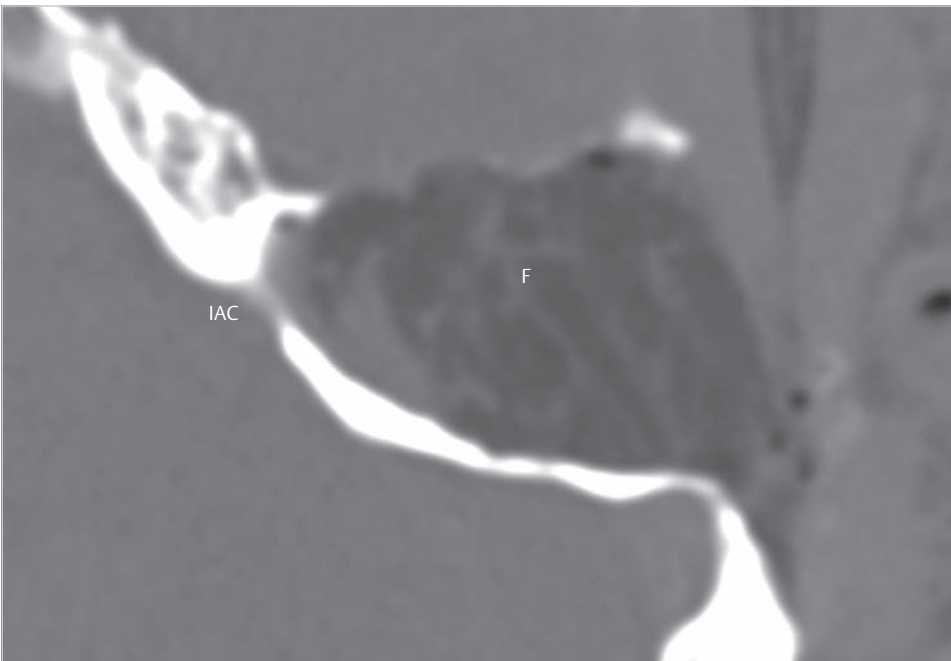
The postoperative CT demonstrates complete removal of the labyrinth. Posterior fossa dura is not uncovered in this case due to anterosuperior localization of the pathology. F, abdominal fat; IAC, internal auditory canal.
